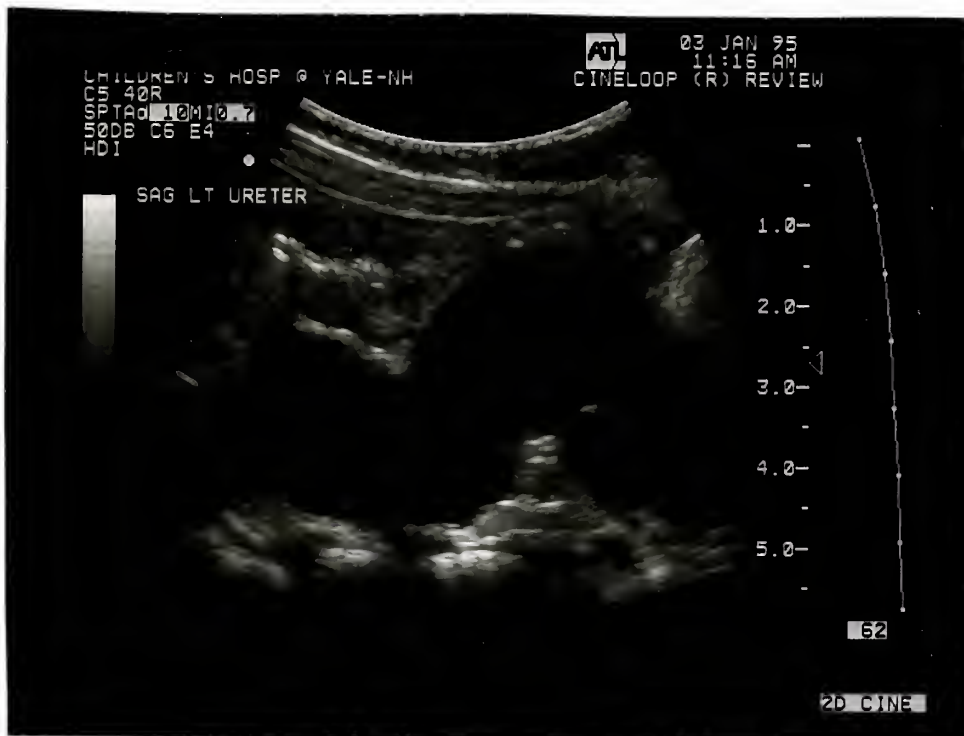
A massively dilated ureter. This left sagittal sonogram demonstrates an obstructed, tortuous ureter measuring 2.33 centimeters in width. The normal ureter is almost never visualized sonographically.
